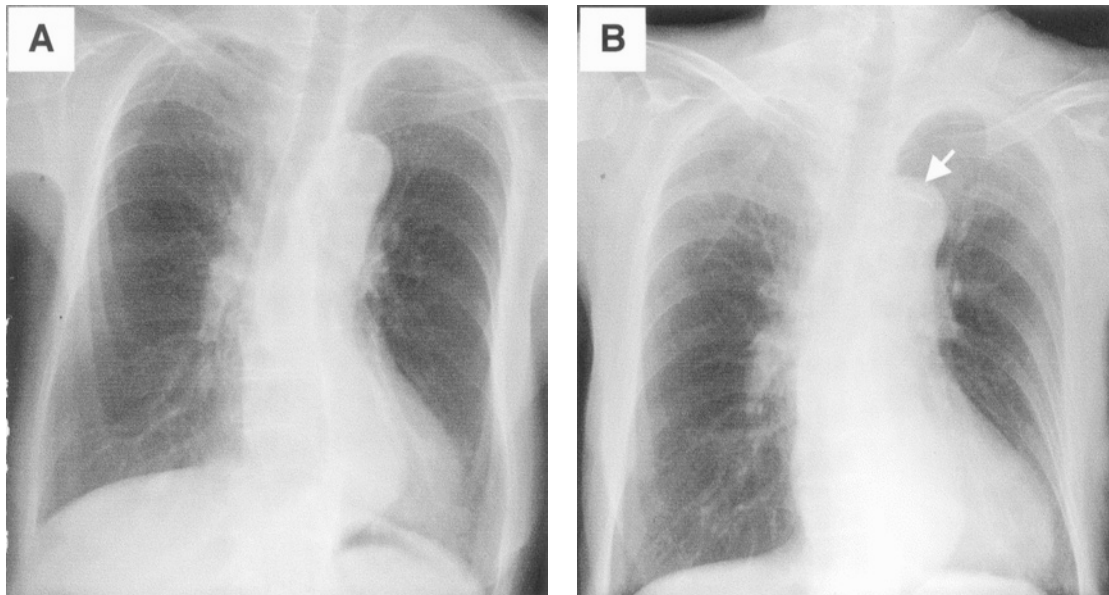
A. Thoracic aorta had kinks and calcification of aortic wall was seen in the chest roentgenogram performed on November 13, 2003. Lung fields were clear and cardiac size was normal. B. A chest roentgenogram showed no mediastinal widening but splitting of calcification of aortic arch was seen (arrow) on November 14, 2003 in addition to the previous findings.
